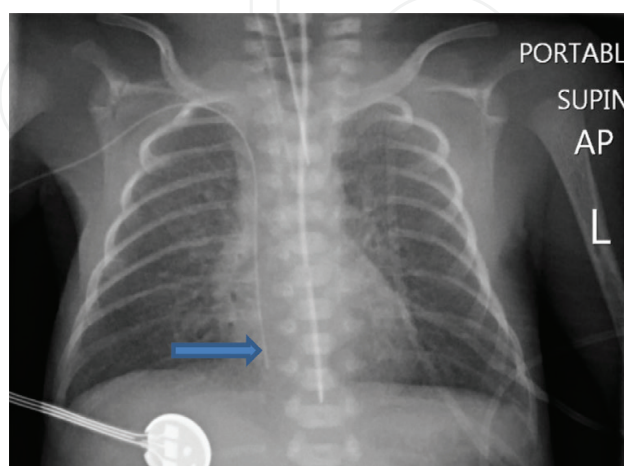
PICC line in the right atrium. Chest X-ray showing right PICC line in the right atrium.
